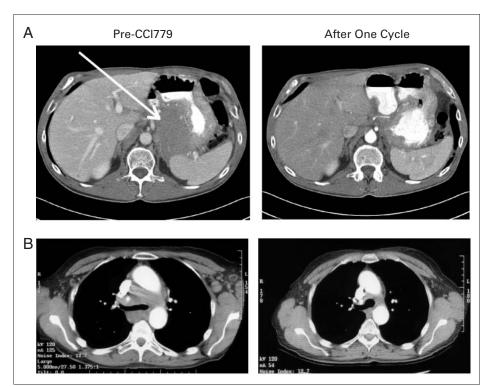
Computed tomography scans from two patients who had marked tumor response after one cycle (four doses) of temsirolimus (CC1779). (A) Patient with a large perigastric lymphomatous mass; (B) patient with bulky paratracheal and left axillary adenopathy.
